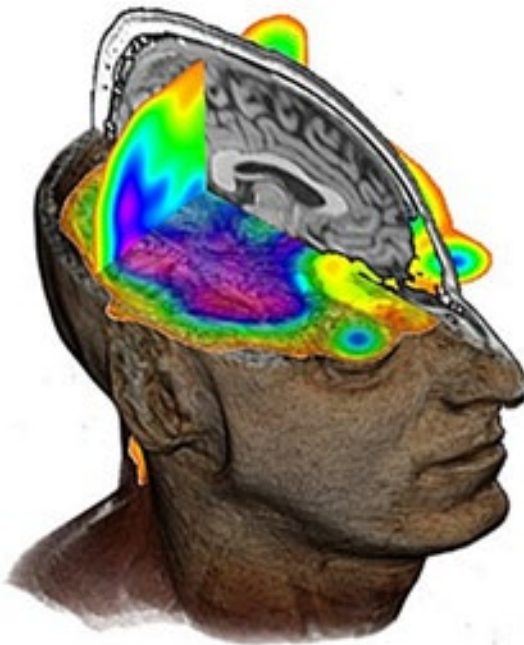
3D MRI of the brain from clinical ^1H MRI data with overlaid ^{17}O MRI in colour. Oxygen MRI data have a lower spatial resolution due to the low concentration of the stable isotope ^{17}O .
